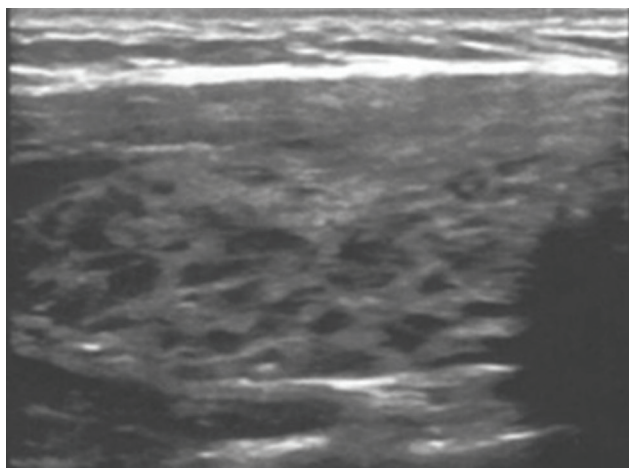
Patient N., 27 years old. Ultrasound of the thyroid gland before the COVID-19 disease. A pseudo-micronodular variant of the “Swiss cheese” type.
